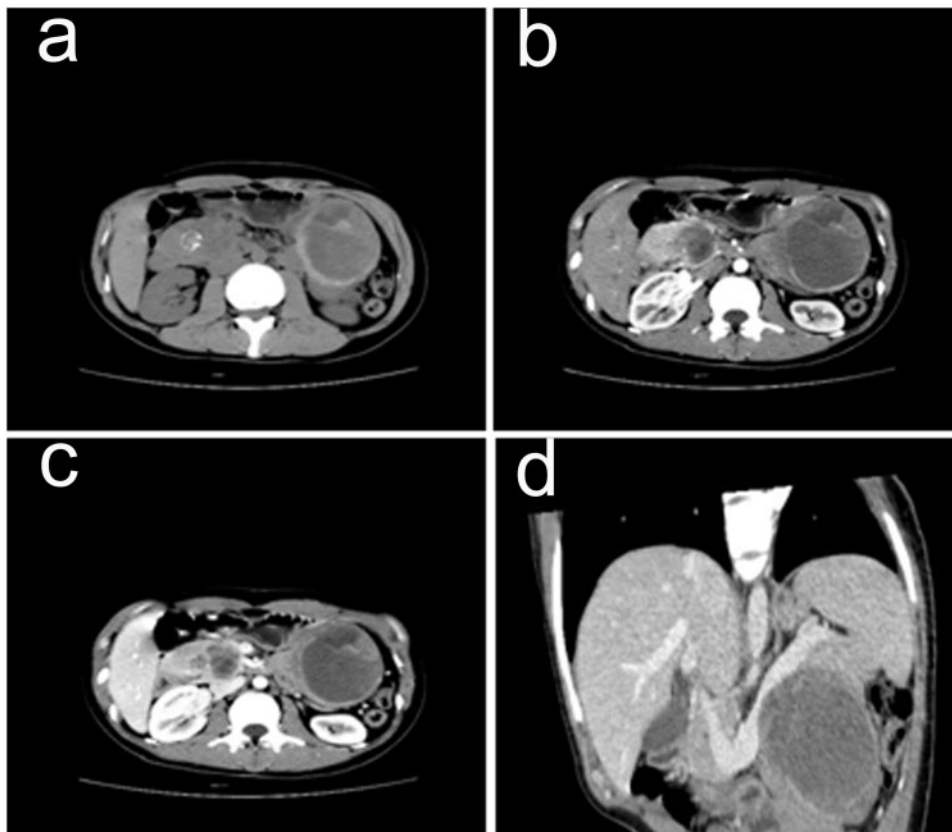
Preoperative abdominal CT images. (a) Unenhanced CT scan shows 2 well-circumscribed heterogeneous lesions: one mass with small cystic areas arising from the head of the pancreas and the other mass with prominent degenerative cystic areas in the pancreatic tail. The typical internal calcification was present in the pancreatic head tumor. (b,c) Solid components of the lesions appeared initially moderately enhanced and a progressive fill-in enhanced pattern during the arterial, portal phase. (d) Multiplanar reformed images demonstrated that the neoplasm in the tail of the pancreas compressed the splenic vein with a smooth border.
